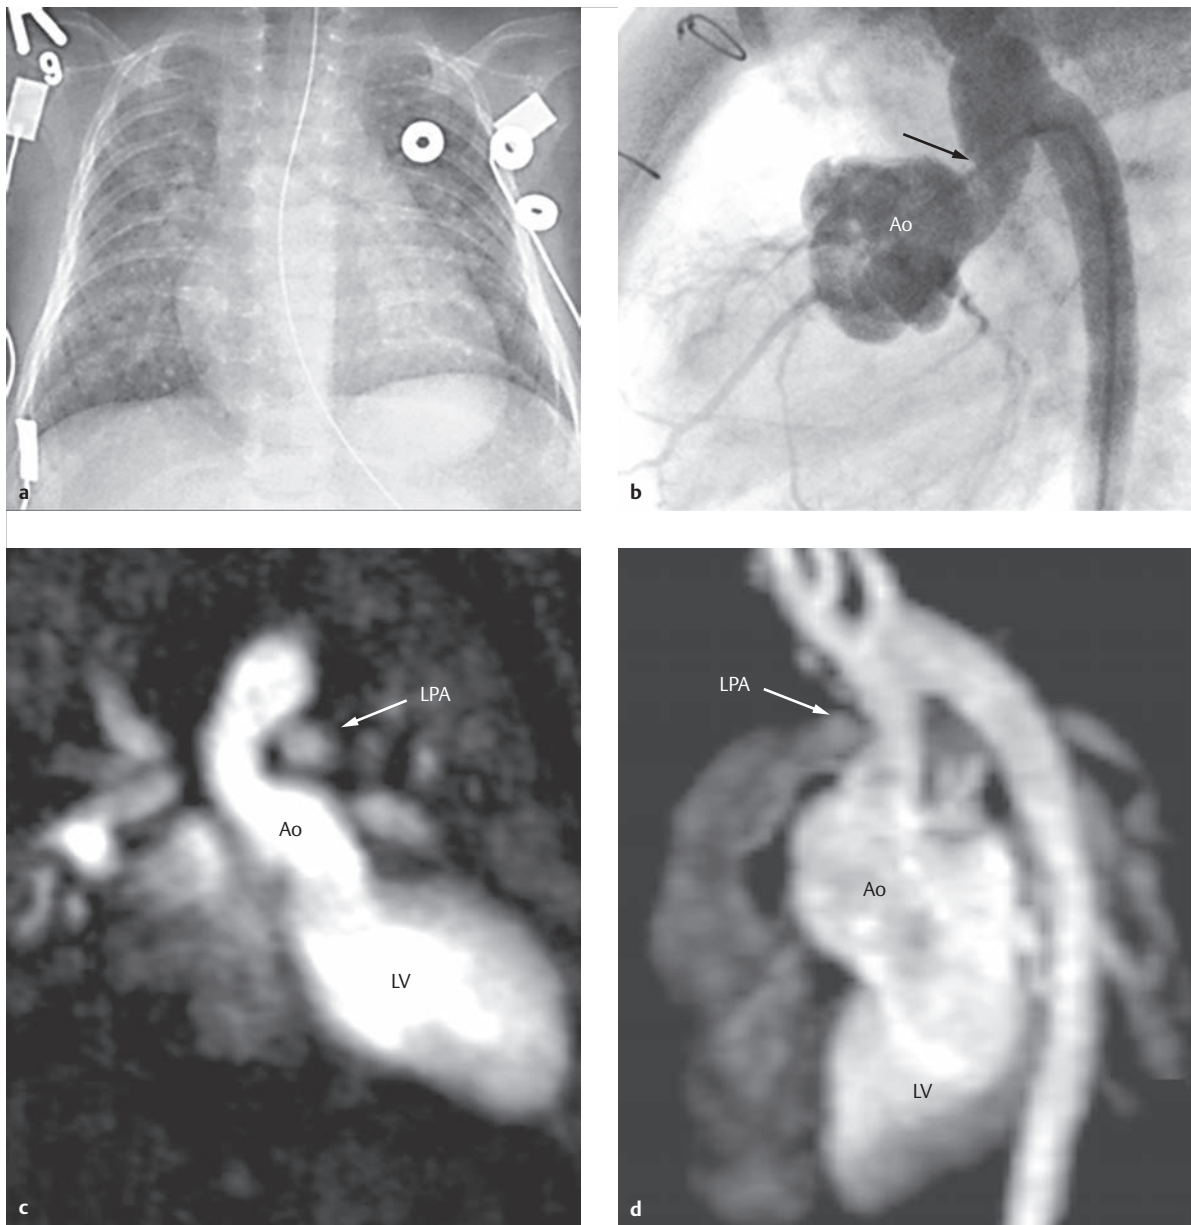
Condition before and after surgical correction of type A₁ (type I) common arterial trunk. The thoracic X-ray (a) depicts an enlarged heart and volume overload in the lungs. A relative stenosis of the ascending aorta (b, arrow), dilated aortic root, and reconstructed aortic arch are visible via invasive angiography. The SSFP cine MRI (c) and 3-D MIP reconstruction (d) indicate the close spatial relationship between the left pulmonary artery and the relative ascending aorta stenosis after performing the Lecompte maneuver.
